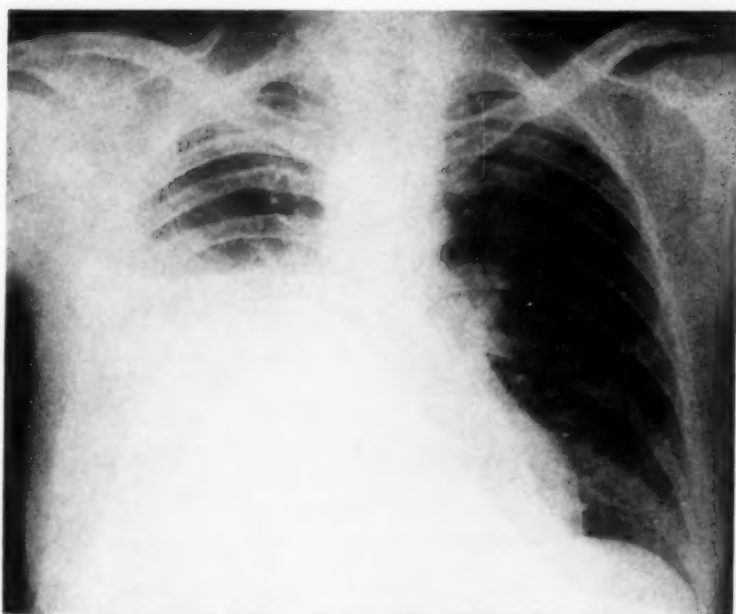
Chest x-ray taken the following morning showing a right pleural effusion.
